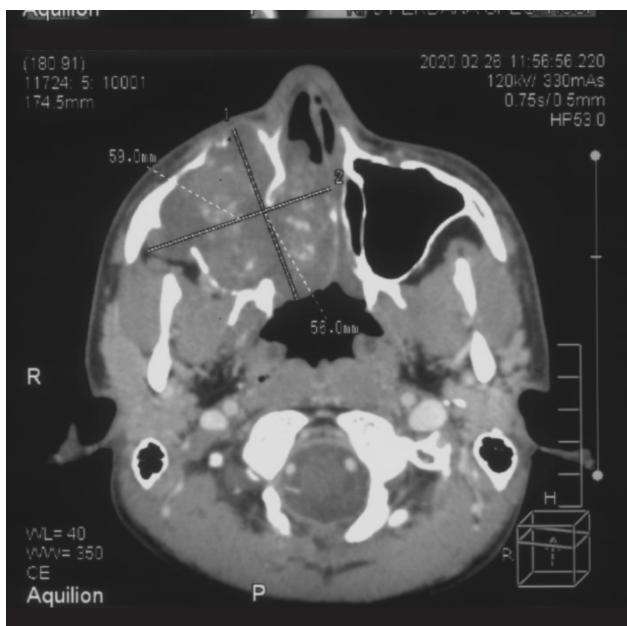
An axial view of a contrast-enhance computed tomography scan of the paranasal sinus in soft tissue window shows right maxillary tumour with uneven contrast enhancement
